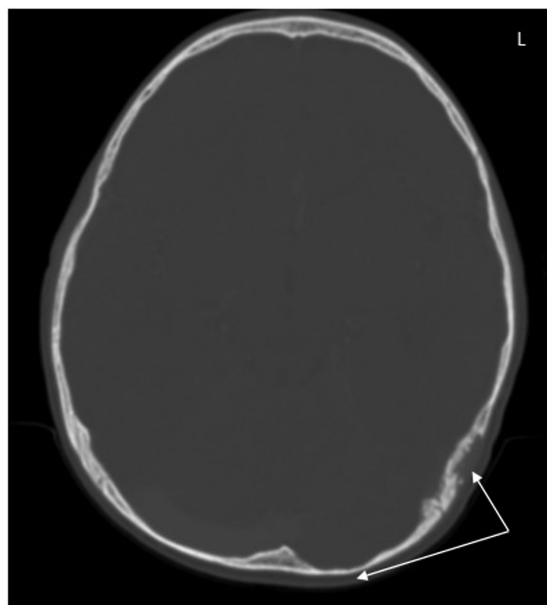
Contrast-enhanced computed tomography of the brain showing thinning and irregular contour (arrows) of the left (L) parietal and occipital bones.
